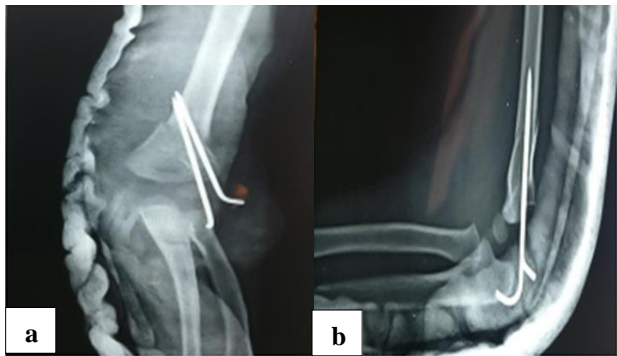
(a and b): Post-operative X-ray.
